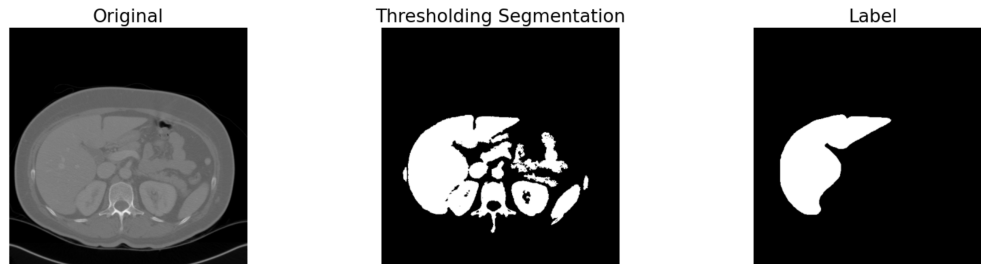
CT liver intensity threshold segmentation.
